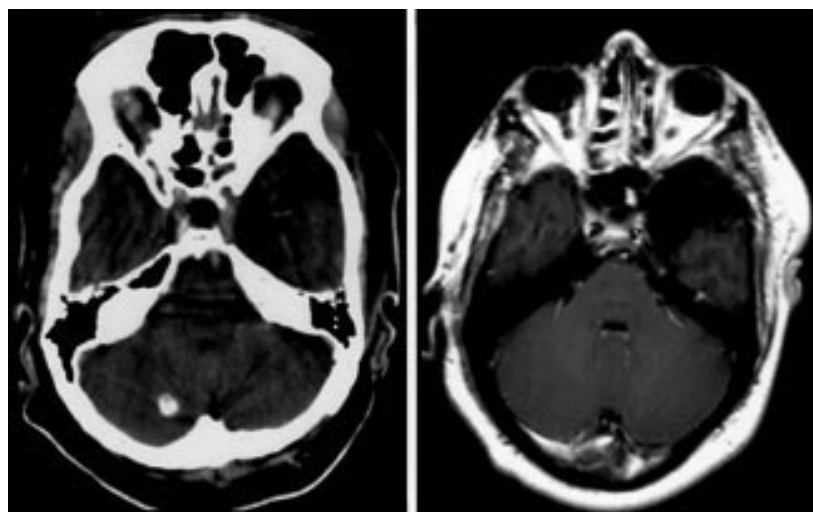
(Left) CT scan of the head showing asymmetry of the skull vault, intracranial calcification within the right cerebellar hemisphere, and a possible cystic lesion in the left parietal area. (Right) Magnetic resonance imaging (MRI) scan of the brain showing lipomas within the subcutaneous fat of the scalp, intracranial lipomas, and an arachnoid cyst anterior and inferior to the left temporal lobe.
